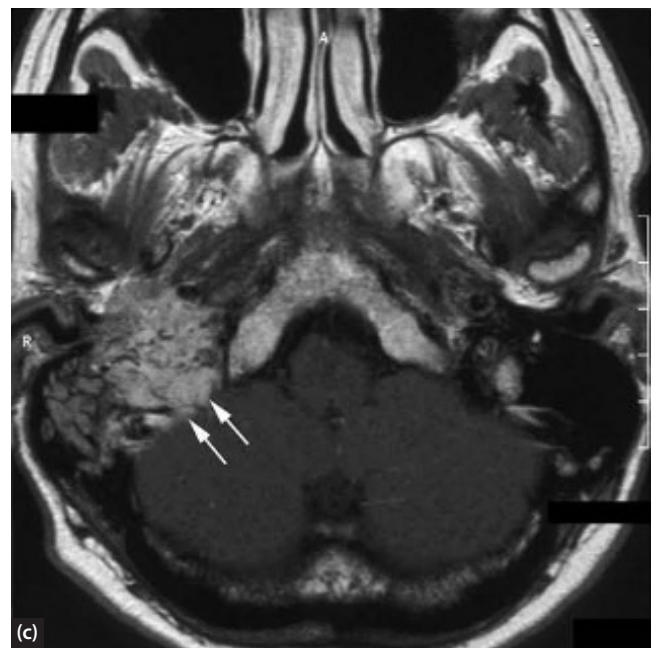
A 42-year-old woman presented with a mixed sensorineural-conductive hearing loss of about 50 dB on the right side in combination with a reddish-blue discolouration of the tympanic membrane. (a) T2-weighted axial MRI showing the lesion in the axial plane (arrows). (b) T1-weighted coronal slices, showing the involvement of the jugular bulb and the sigmoid–jugular complex (arrows). (Continued)
